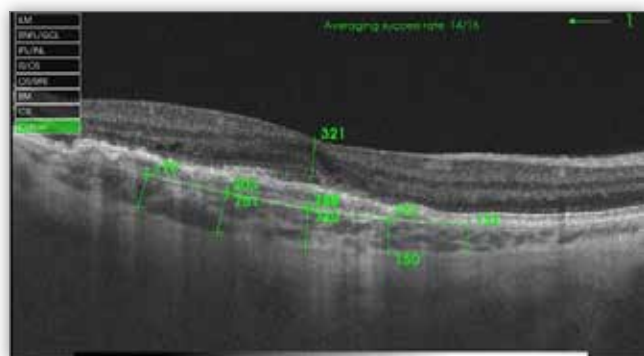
Radial, horizontal optical coherence tomography B-scan passing through the fovea; CRT measured from ILM to the outer border of RPE at the center of the fovea; 321 μm . CT measured at five locations from the outer edge of the hyperreflective line corresponding to the RPE to the outer edge of choroidal stroma. SFCT – 207 μm , CT750N – 150 μm , CT1500N – 132 μm , CT750T – 203 μm , CT1500T – 170 μm .
